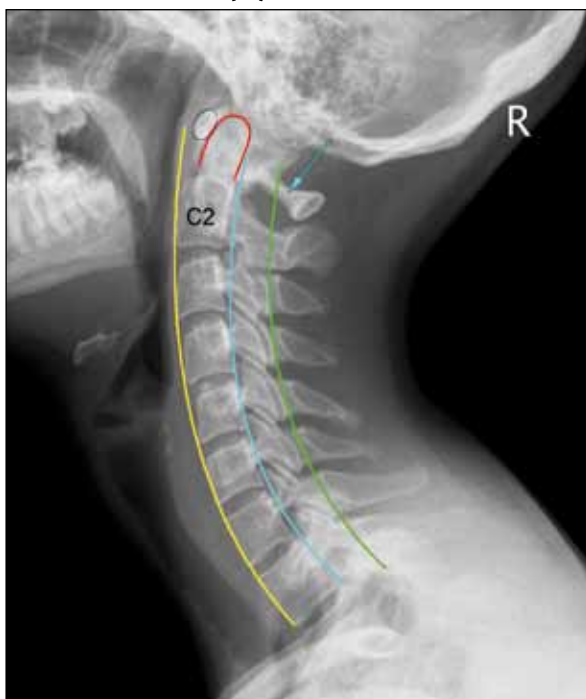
Normal lateral cervical spine radiograph demonstrates the three lordotic curves. The odontoid peg is outlined in red and the anterior arch of atlas (C1) is circled.
